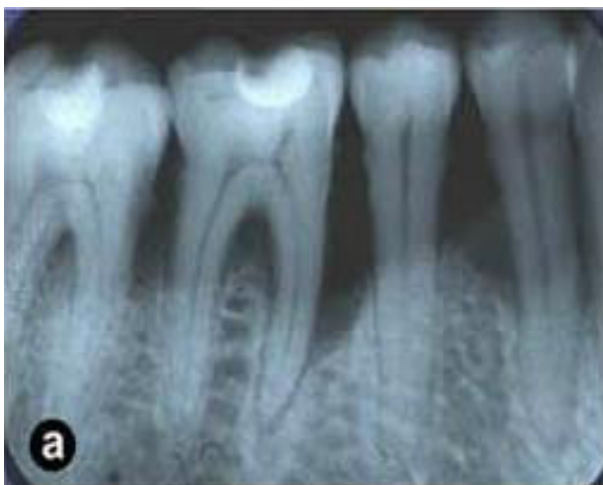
Case A. X-Ray images before treatment (a) and six months after (b)
